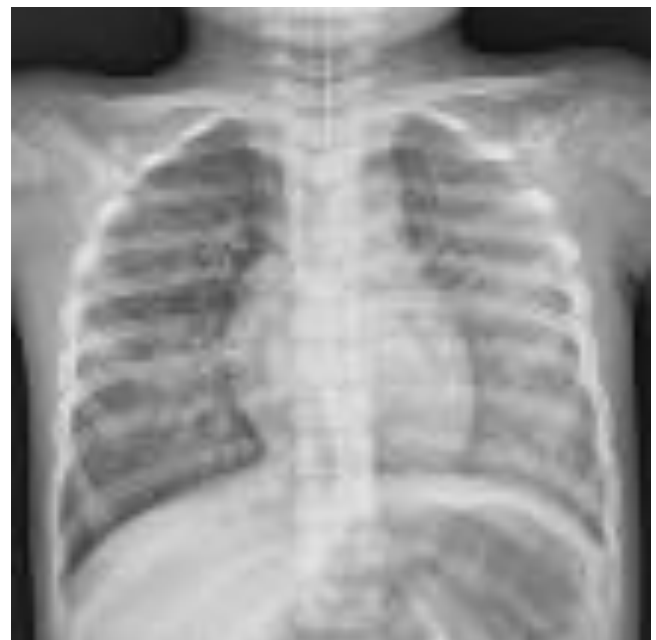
Chest radiograph of a patient with enterovirus 71 infection presenting with pulmonary hemorrhage and shock. Note the diffuse haziness on both lungs.
